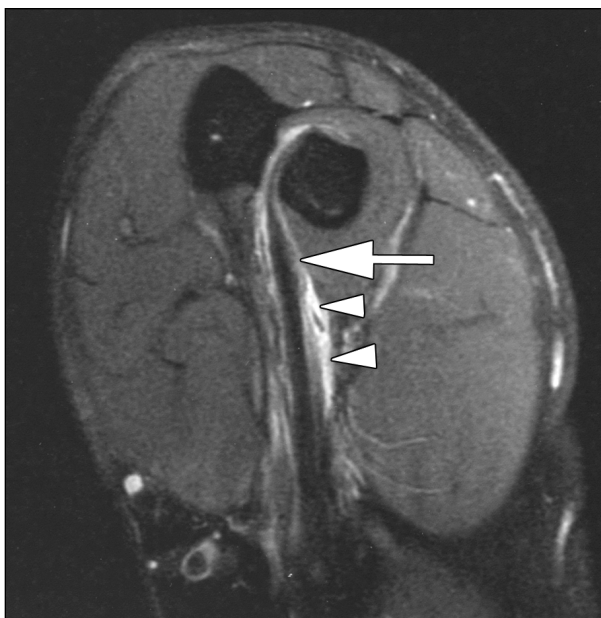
53-year-old man with partial tear of right distal biceps brachii tendon. Proton density fat-suppressed MR image (TR/TE, 3,000/45) shows flexed abducted supinated view with partial tear and fluid around tendon. Arrow = abnormal signal of partial tear, arrowheads = fluid around distal tendon.
